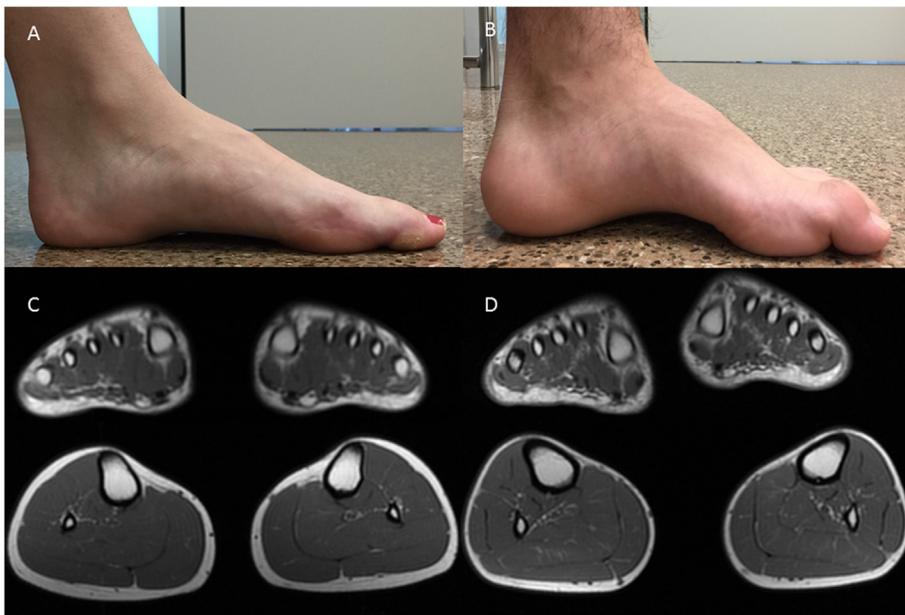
Clinical images and muscle MRI (T1 weighted images shown). A Mild pes cavus of patient II:1. B Moderate pes cavus with hammer toes of patient II:2. C Muscle MRI of patient II:1 showing no fat replacement at the level of the feet and calf. D Muscle MRI of patient II:2 showing no significant abnormalities of either the feet or calf.
